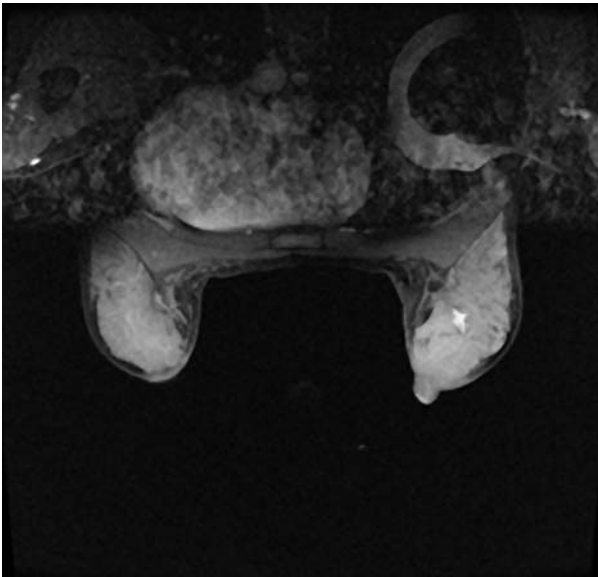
Bilateral MRI acquired in axial orientation shows a brightly enhancing mass corresponding to a fibroadenoma in the left breast of a patient with very dense breast tissue. Note aliasing of signal from the arms and image blurring due to motion artifact seen posterior to chest wall. Assignment of the phase encoding direction to the left-right direction minimizes artifact-related image degradation in the breast tissue. (Reproduced with permission from American College of Radiology (ACR). ACR BI-RADS®–Magnetic Resonance Imaging. In: *ACR Breast Imaging Reporting and Data System, Breast Imaging Atlas*. Reston, VA. American College of Radiology; 2003.)
